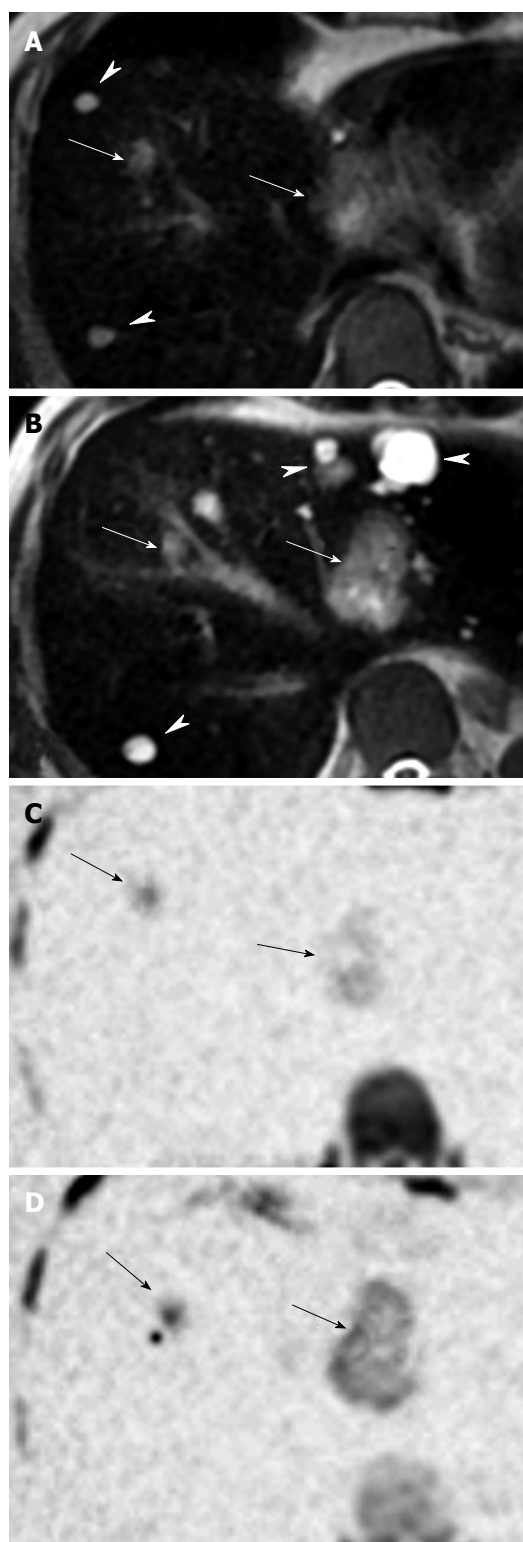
A case of multiple hepatic metastases of colon cancer with multiple hepatic cysts. A, B: T2-weighted magnetic resonance imaging showing high signal intensities on both metastatic lesions (arrows) and cysts (arrow heads); C, D: Diffusion-weighted imaging after administration of superparamagnetic iron oxide showing high signal intensities on metastatic lesions only (arrows).
